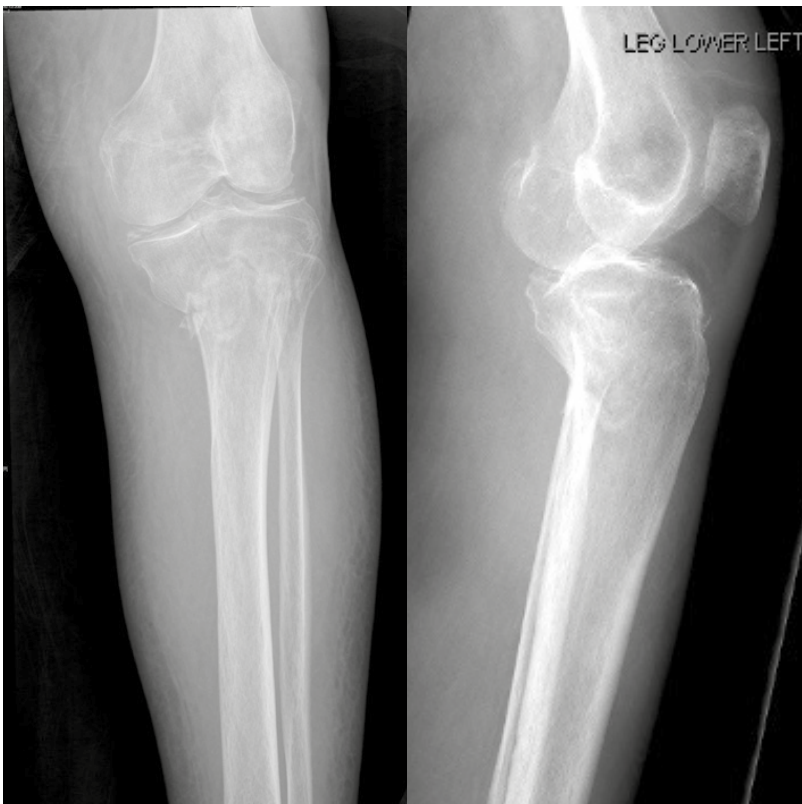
Pre-operative anterior x-ray of tibia plateau fracture.
